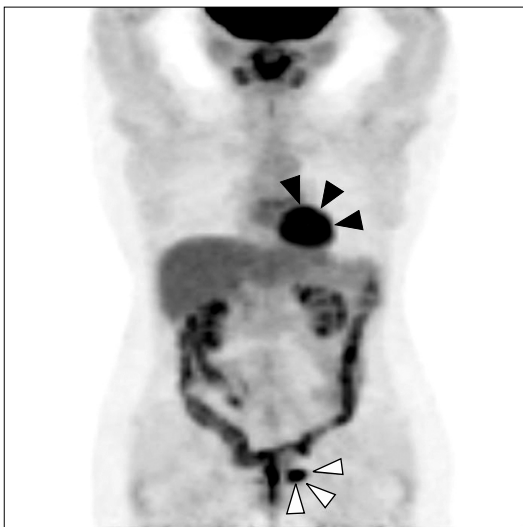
An F-18 fludeoxyglucose positron emission tomography (FDG-PET) scan revealed a high-uptake lesion in the wall of the gastric antrum (arrowheads) and presacral area (white arrowheads).
